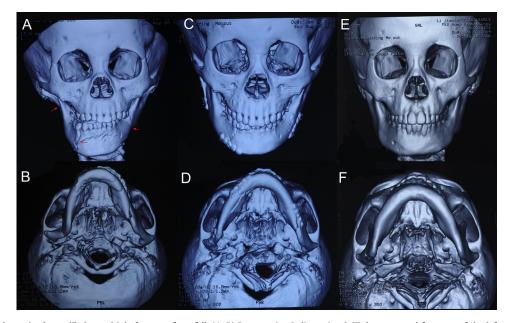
A 4-year-old girl sustained mandibular multiple fractures from fall. (A, B) Preoperative 3-dimensional CT demonstrated fractures of the left angle, the right parasymphysis and the right condylar neck (red arrow). (C, D) Postoperative CT after open reduction and internal fixation. (E, F) CT scan 2.5 years after the operation showing well fracture healing and symmetric contour of the mandible.
